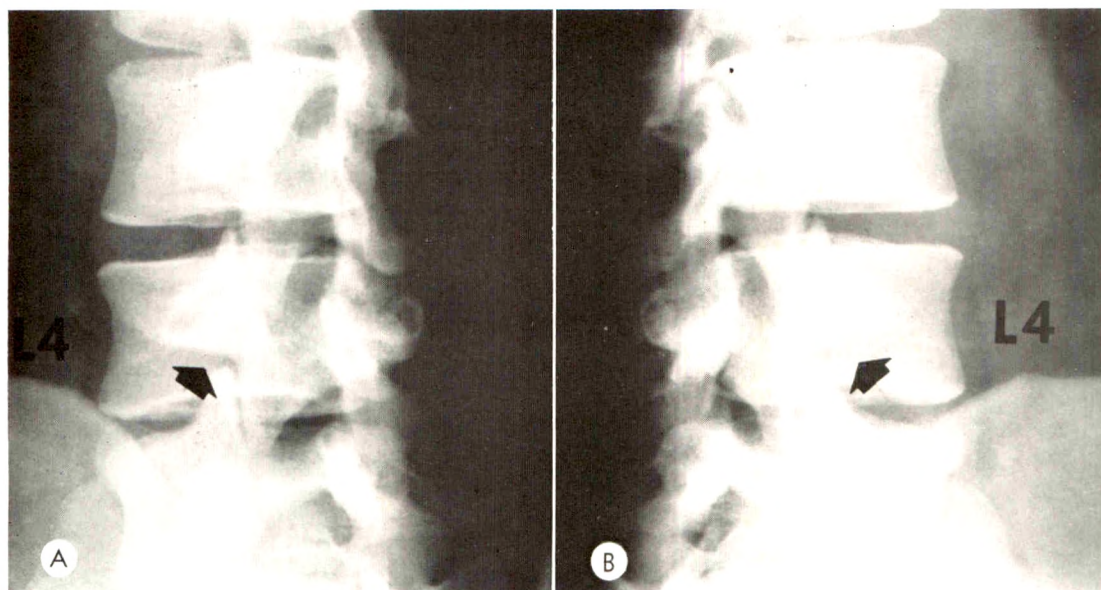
(*A* and *B*) Oblique roentgenograms obtained in 1964 show complete healing of bilateral pars interarticularis fractures.
